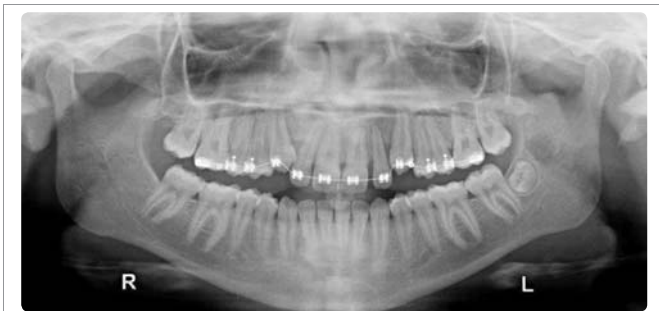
Panoramic radiograph taken during Treatment after 12months.
